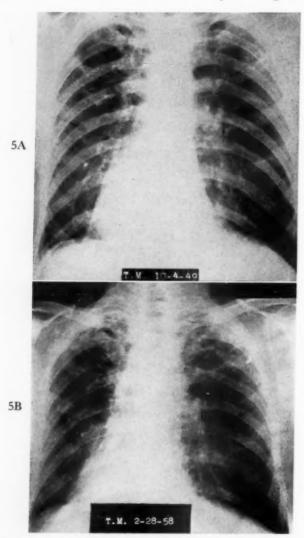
Case II. A and B, chest roentgenograms taken approximately eight years and four months apart, showing essentially static appearance of bilateral apical and hilar infiltrates due to H. capsulatum.
